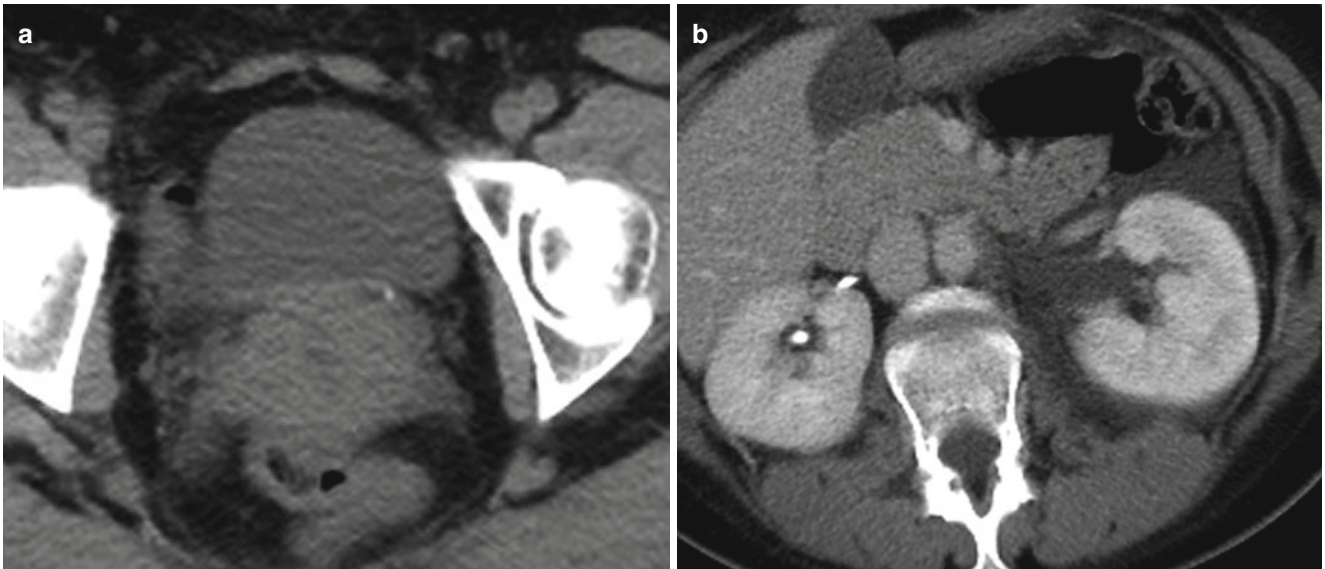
Forniceal rupture in a 41-year-old female with left flank pain. (a) Non-contrast-enhanced axial CT image demonstrates 2 mm left UVJ stone. (b) Contrast-enhanced CT axial image demonstrates perinephric fluid consistent with fornix rupture
